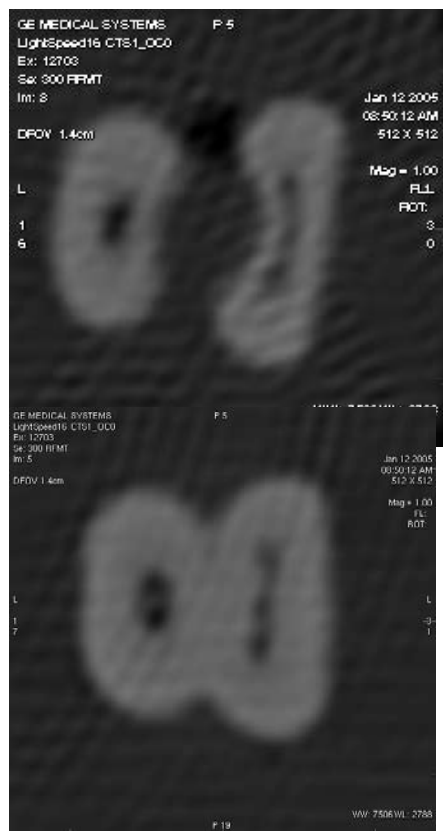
CT of two mandibular first molars with three canals in the mesial root (cross-sections at middle and apical thirds).
